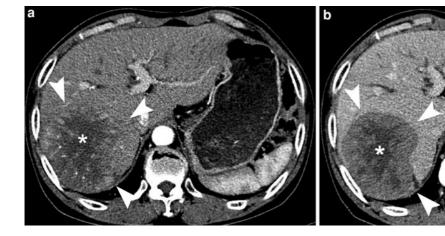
Poorly differentiated HCC with central necrosis. a Arterial phase CT scan shows a heterogeneously enhancing tumor (*arrowheads*) with central necrosis (*asterisk*). b Delayed
